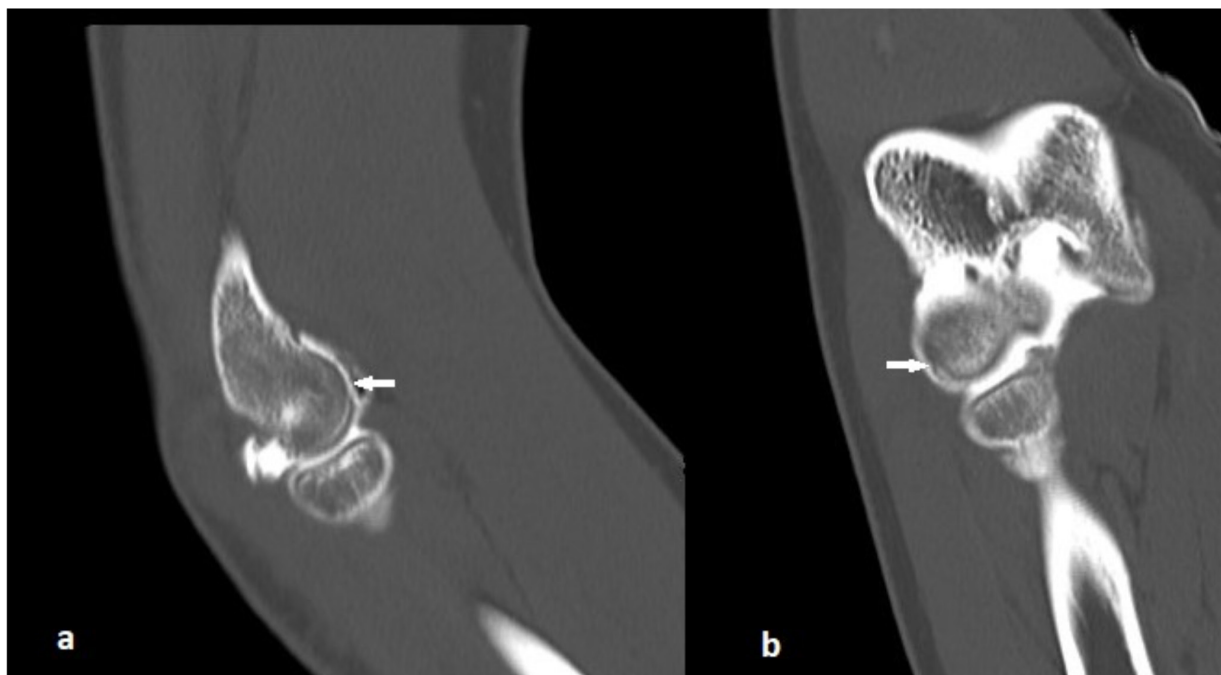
Sagittal (a) and coronal (b) CT-arthrography images demonstrating a chondral erosion of the lateral aspect of the capitellum, i.e., CLAC (white arrows).
